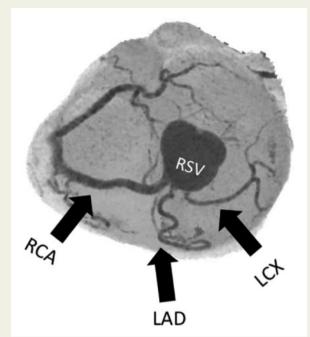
Coronary computed tomography angiography showing the separate ostia of the three coronary arteries from the right sinus of Valsalva, pre-pulmonic course of left anterior descending artery, and septal course of left circumflex artery.
